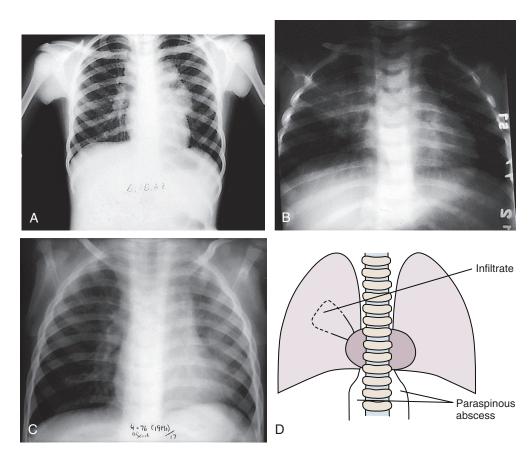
Primary pulmonary tuberculosis. A, Marked enlargement of hilar nodes without a pulmonary infiltrate is seen in this asymptomatic child. She was tested as part of a contact investigation, and this chest radiograph was obtained because her skin test was positive. B, A hazy infiltrate involving a segment of the right upper lobe is seen extending from the hilum to the pleura. This child also has tuberculous spondylitis with a paraspinous abscess, the shadow of which is seen below the diaphragm (D). C, In this boy who presented with a pneumonic clinical picture, a hazy infiltrate occupies the entire left upper lobe. (*A and B*, *Courtesy Jocelyn Medina*, *MD*; C, courtesy Richard Towbin, *MD*, *Children's Hospital of Philadelphia*, *Philadelphia*, *Pa*.)
